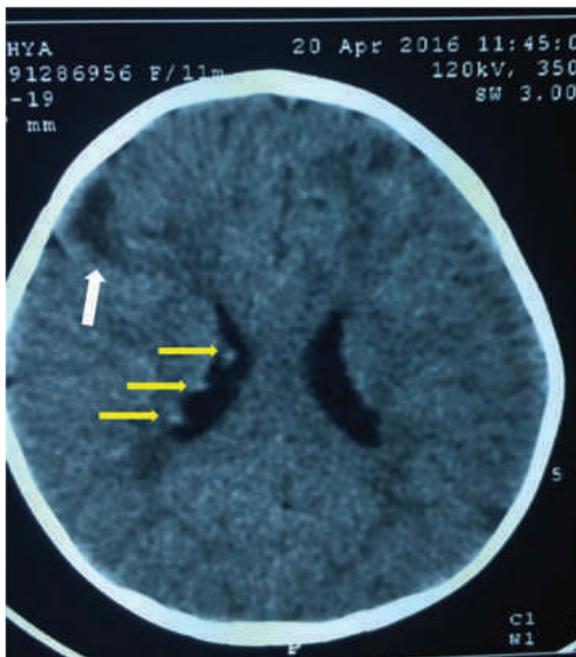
CT Brain showing multiple subependymal nodules (yellow arrow) and cortical tuber (white arrow)
